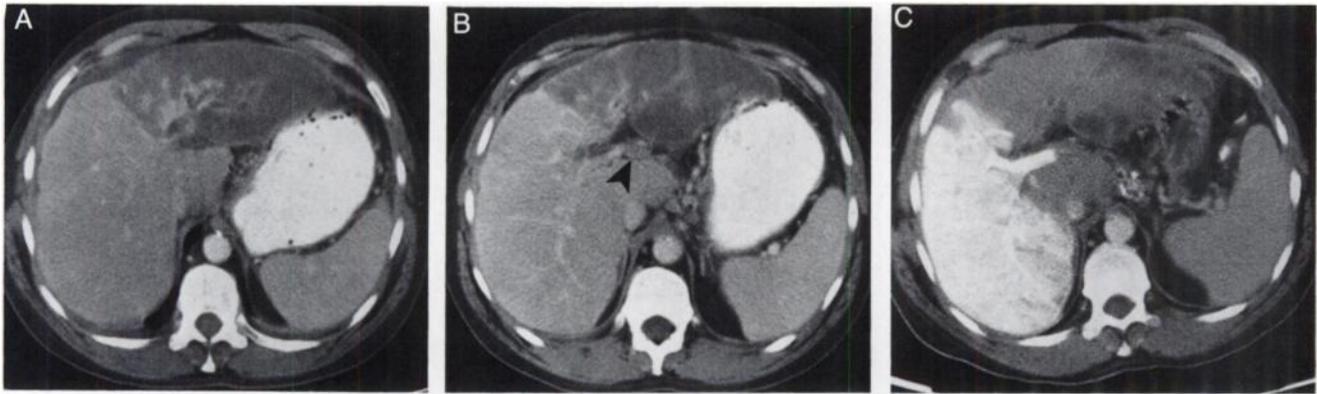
(A) Intravenous contrast-enhanced CT demonstrates hypodensity throughout the left lobe of the liver consistent with infarction. The enhancing periportal tissue proved to be cholangiocarcinoma at percutaneous biopsy. (B) Inferior CT image demonstrates the lack of enhancement of the left portal vein (arrow) consistent with portal vein occlusion. (C) CT arterial portography demonstrates left portal vein occlusion with lack of enhancement of the left lobe, caudate lobe and portions of the anterior segment of the right lobe of the liver.
